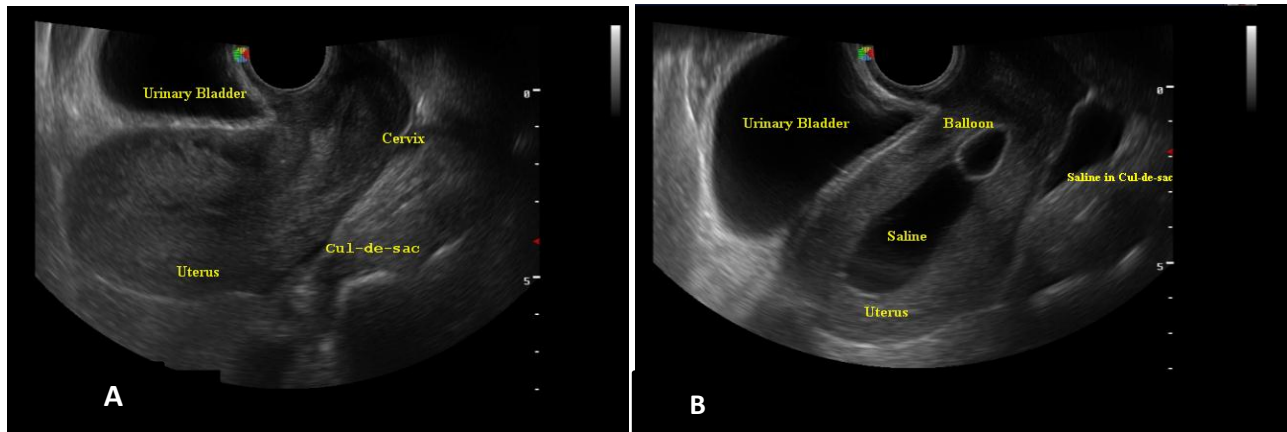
Normal SISHG study: Sagittal transvaginal ultrasound of a 29years old lady with secondary infertility before saline infusion (A) and after saline infusion (B) showing well distended, smoothly outlined endometrial cavity and adequate amount of saline within the posterior cul-de-sac after infusion of saline likely showing patent fallopian tubes. Tikur Anbessa Hospital, 2019.
